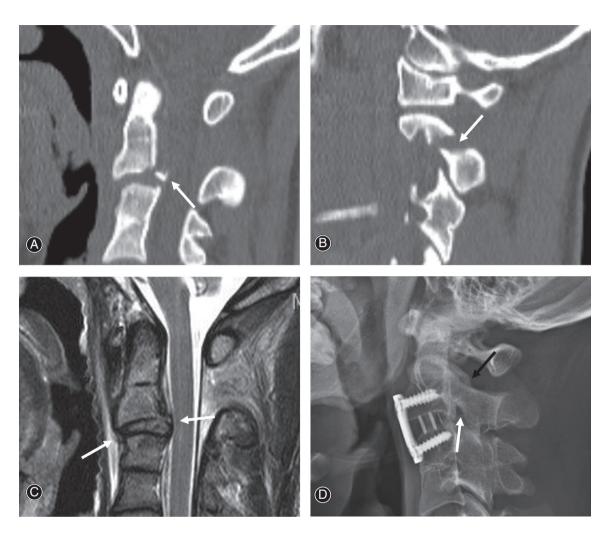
Sagittal and parasagittal computed tomography (CT) scans showing $C_{2\cdot3}$ anterior slip and posterior tear drop (TD) fracture (white arrow) (A) and hangman's fracture (white arrow) (B). Sagittal magnetic resonance imaging (C) showing $C_{2\cdot3}$ discoligamentous injuries (white arrows). At 44 months follow-up after surgery, lateral X-ray (D) showing solid fusion of $C_{2\cdot3}$ anterior cervical discectomy and fusion and fractures of pedicle (white arrow) and lamina (dark arrow).
